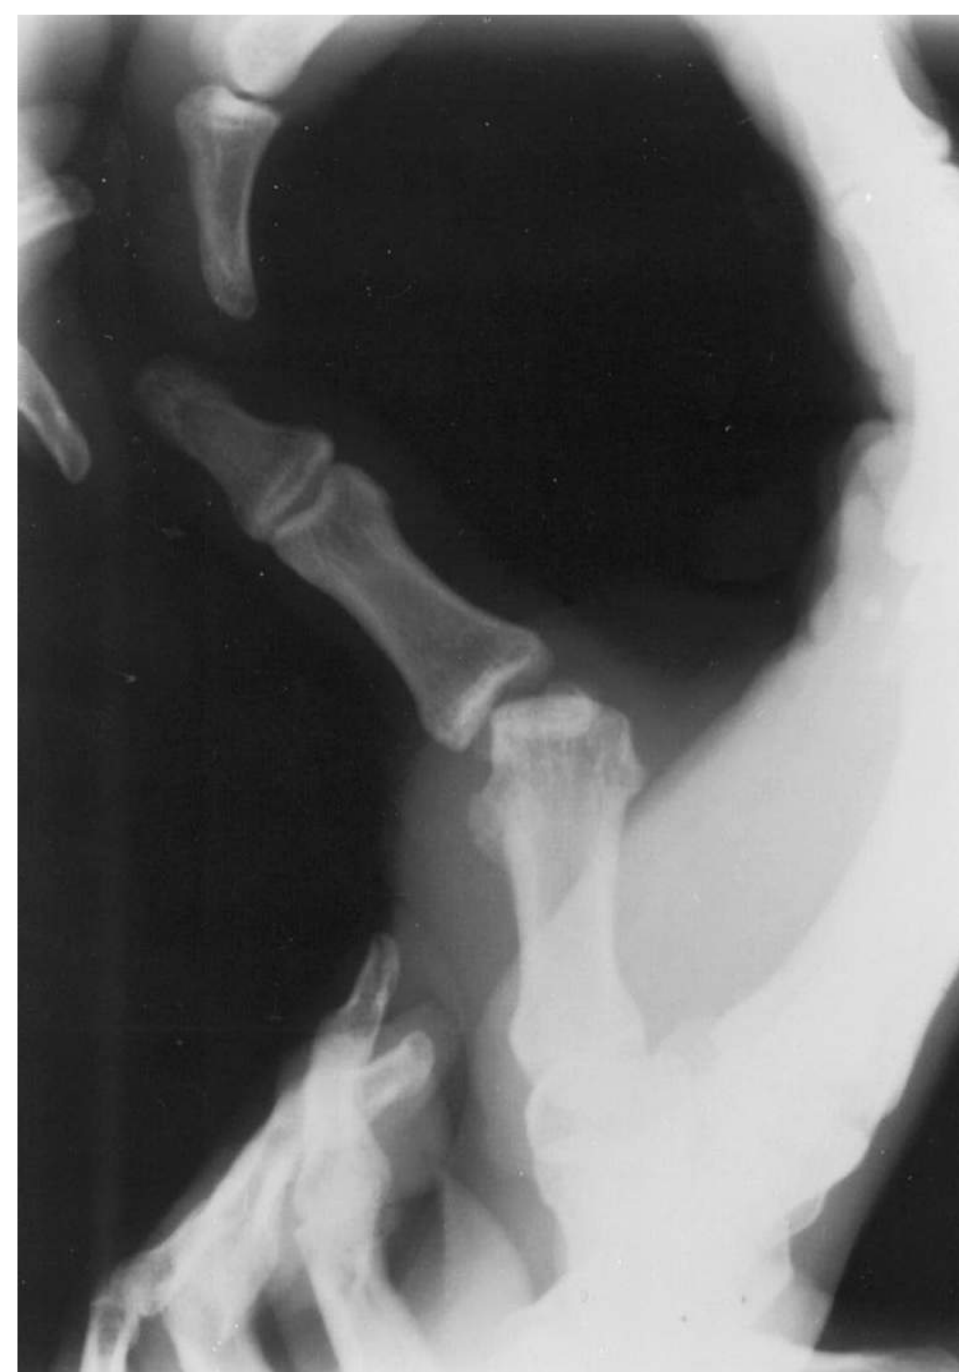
■ Gamekeeper’s Thumb. Stress x-ray of a thumb with a complete ulnar collateral ligament tear demonstrates marked instability of the ulnar side of the MCP joint and radial deviation of the proximal phalanx. (Used with permission from Brunickardi FC, Anderson DK, Billar TR, et al. *Schwartz’s Principles of Surgery*. 8th ed. New York: McGraw-Hill; 2005. © 2005 by The McGraw-Hill Companies, Inc.)
